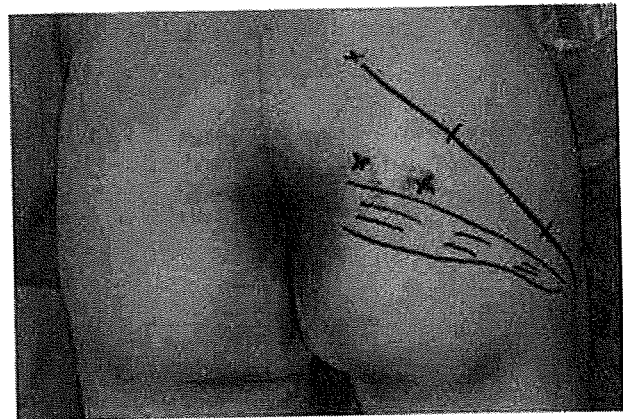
Damaged skin surrounding the fistula before surgery. A skin perforator (2 x's) from the superior gluteal artery was marked with a Doppler flowmetre.
